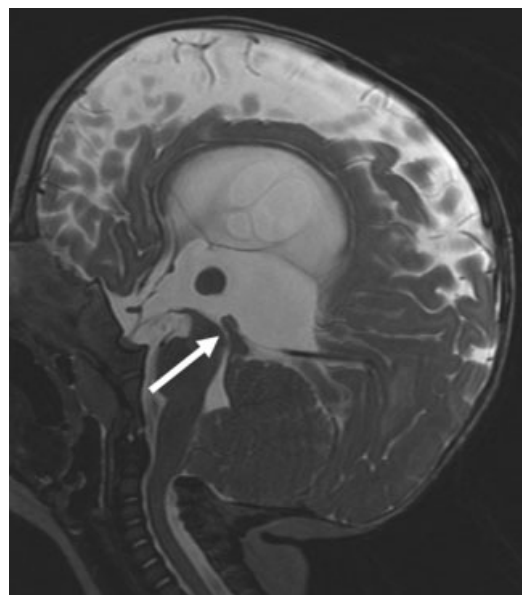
MRI at the 8 months of age; sagittal T2-weighted fast spin echo sequence: small posterior fossa, no cerebellar herniation. Dysplastic mesencephalic tectum and missing flow void at the level of the cerebral aqueduct (arrow). MRI, magnetic resonance imaging.
